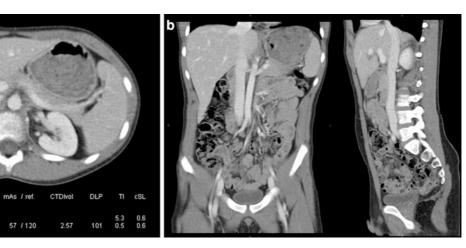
Iodine enhanced abdominal MDCT in a 12-year-old boy weighting 45 kg complaining of right iliac fossa pain. No sign of appendicitis was found by CT. Tube potential is at 100 kV and reference image quality index is set at 120 mAs.
